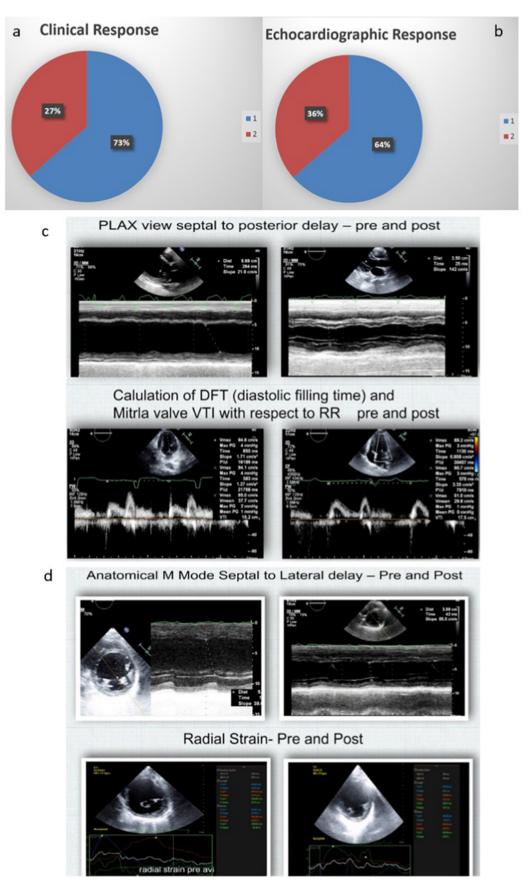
a, b: shows Clinical and Echocardiographic responders (blue) and non-responders (red), c: PLAX Septal to posterior delay – Pre and Post CRT, DFT and MVVTI – Pre and post CRT, d: Anatomical M mode Septal to lateral delay – Pre and post CRT; Radial strain – Pre and post CRT.
